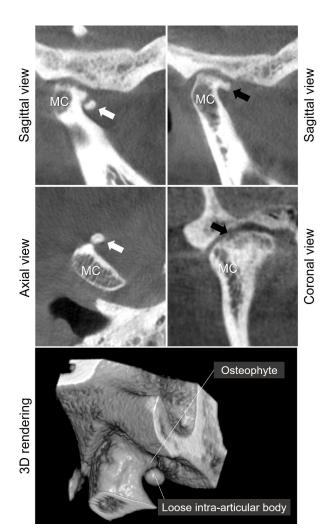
Cone-beam computed tomography scan of the right temporomandibular joint. The sagittal and axial views show the loose intra-articular body (yellow arrow) and osteophyte (white arrow). The coronal view shows discrete erosion of the mandibular condyle cortical (black arrow). MC: mandibular condyle.
